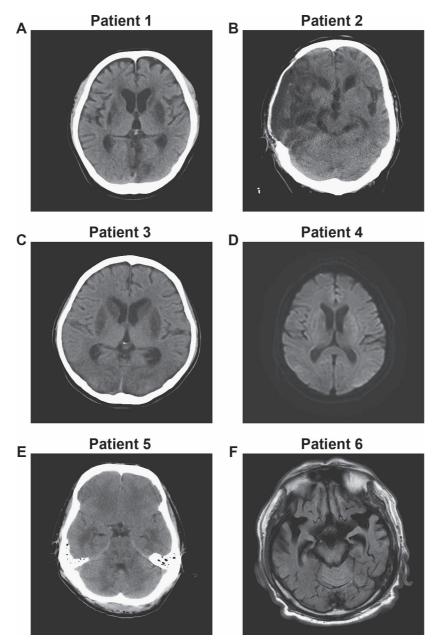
The images of head computed tomography and magnetic resonance imaging.
